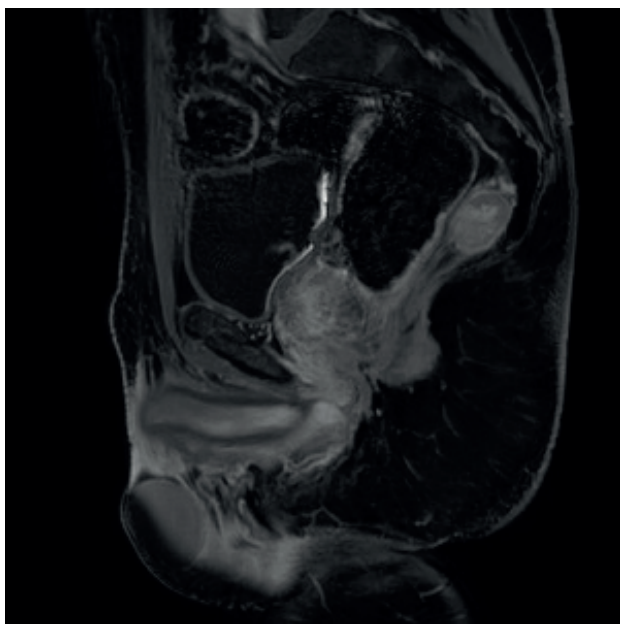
Sagittal view on MRI of a multiloculated/solid paramedian retrorectal neoplasm in DWI/DSI sequences. Here is shown a multicystic oval lesion with a solid portion located in the soft tissues between the cecum and the sacrum.
